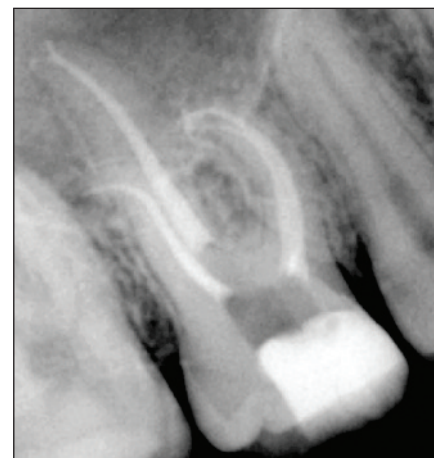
Post-op radiograph of maxillary molar with .04 tapers and BC Sealer. As evidence of the flow ability of this sealer, please note the sealed delta in the palatal root. Courtesy of Dr. Alex Fleury, Dallas.
